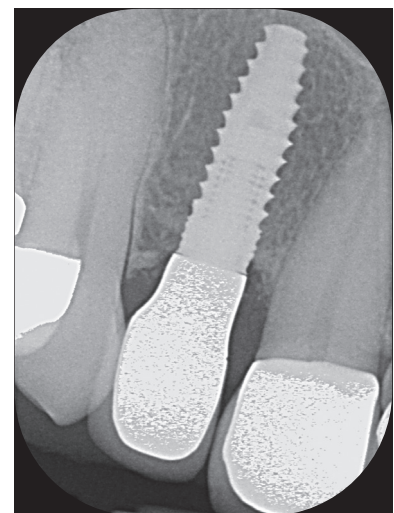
Clinical situation 12 months after restoration. Stable, non-inflamed soft-tissue conditions. Distally almost complete and mesially partial formation of papillary structures. Fig. 2: Radiograph 12 months after restoration. Stable, well-developed osseous structures could be seen around the implant, along with complete integration of the implant. CERASORB Foam had been completely resorbed and replaced by endogenous bone.
